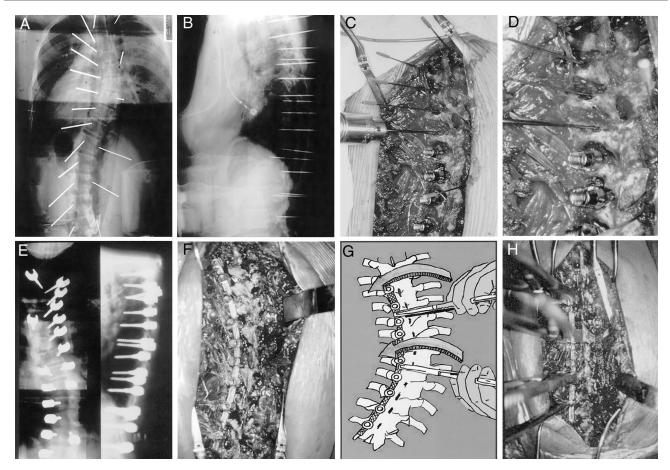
Surgical techniques. (A and B). Guide pins were inserted at the presumed pedicle entry points. Determine the association between the presumed entry point and the ideal pedicle entry point on the radiograph. (C) Pedicle entry by drilling. (D) Confirm a safe entry with a blunt-ended probe. A safe entry is confirmed when the probe meets bony resistance in all directions and cancellous bone at the tip. (E) Screw insertion. Screws are inserted on every segment on the correction sides (thoracic concave) and every second or third on the support side. (F) Rod insertion. (G) Deformity correction by derotation without compression–distraction. (H) After derotation.
